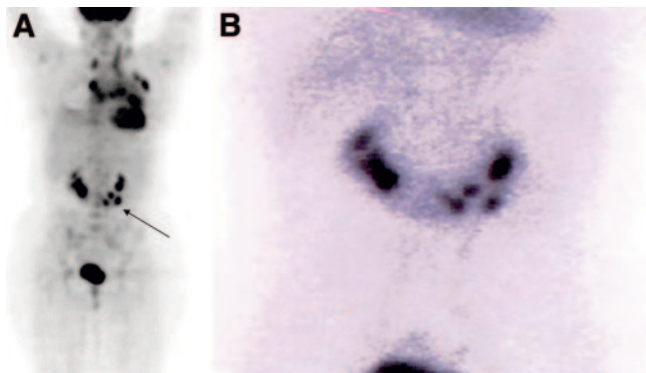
Horseshoe kidney. (A) Horseshoe kidney (arrow) seen on ^{18}F -FDG PET scan (projection view on left). Patient with Hodgkin's lymphoma. (B) $^{99\text{m}}\text{Tc}$ -Glucoheptonate scan confirms presence of horseshoe kidney.
